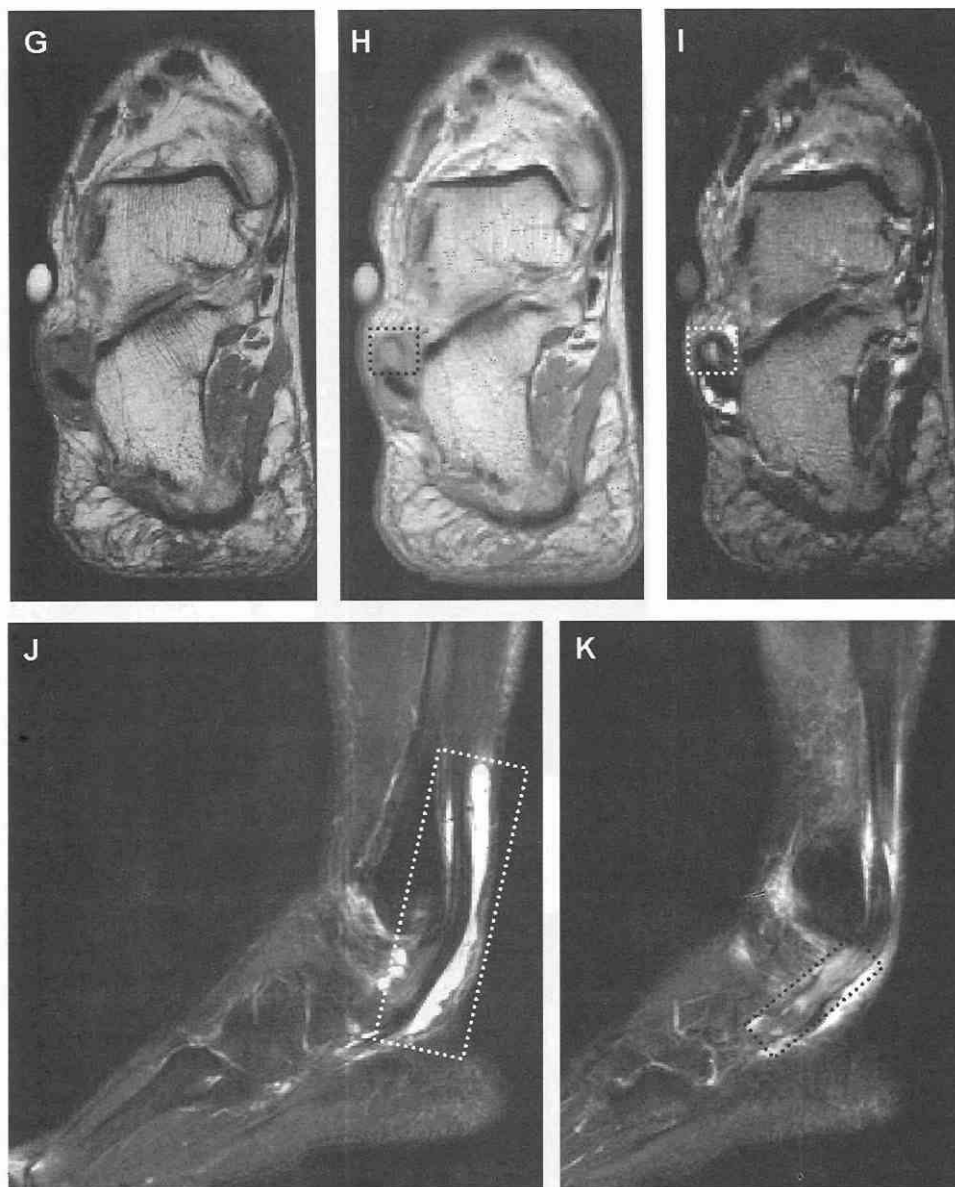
Continued. G-I, Coronal T1-weighted, proton-density-weighted, and T2-weighted images reveal abnormal signal within the substance of the peroneal brevis tendon (*dotted squares*). The marker is over the point of maximum tenderness.
